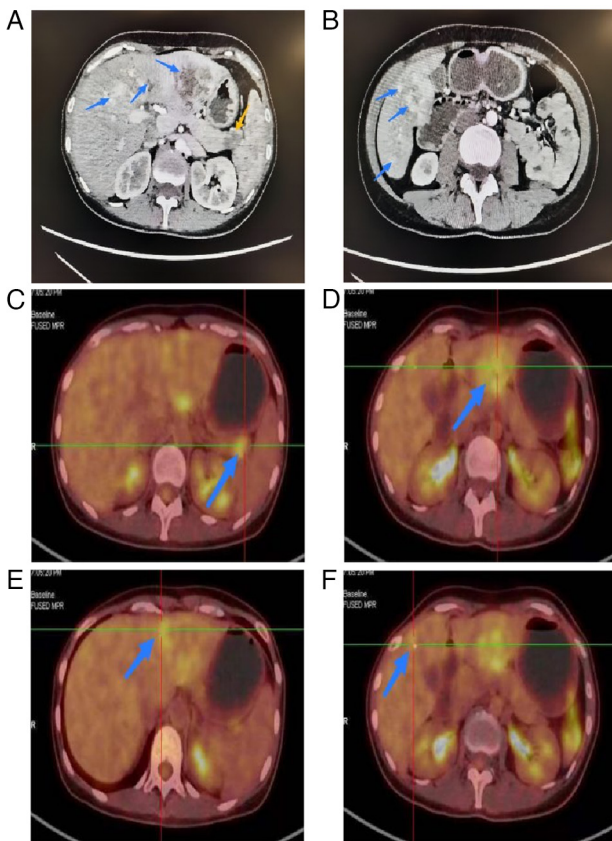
Abdominal imaging studies prior to surgery. (A and B) Enhanced CT showing a mixed-density nodule (1.9x1.6 cm) at the tail of the pancreas and multiple hepatic lesions (yellow arrows indicate pancreatic lesions; blue arrows indicate liver metastases). (C-F) Positron emission tomography-CT images of (C) the same pancreatic nodule displaying increased metabolism (SUV_{max} , 3.6) and (D-F) multiple, somewhat low-density lesions of the liver (SUV_{max} , 4.5) with uneven metabolic activity (malignancy not excluded) (blue arrows indicate liver metastases). CT, computed tomography; SUV_{max} , maximum standardized uptake value.
